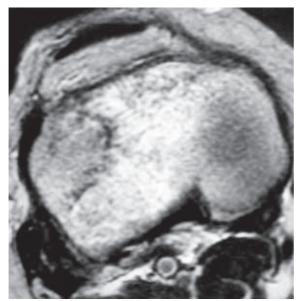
Axial T2-weighted MR image of the tibial condyle shows a hypointense curvilinear fracture line with adjacent hyperintense bone oedema.
